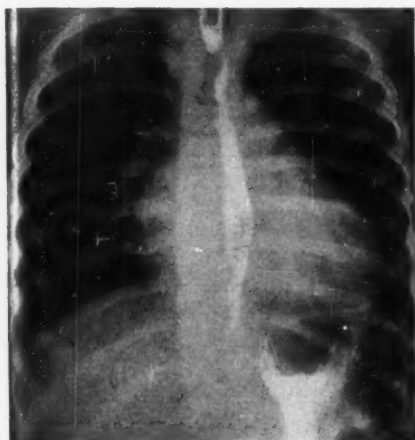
Roentgenogram of patient 10, with a dominant ventricular septal defect and a right aortic arch.
